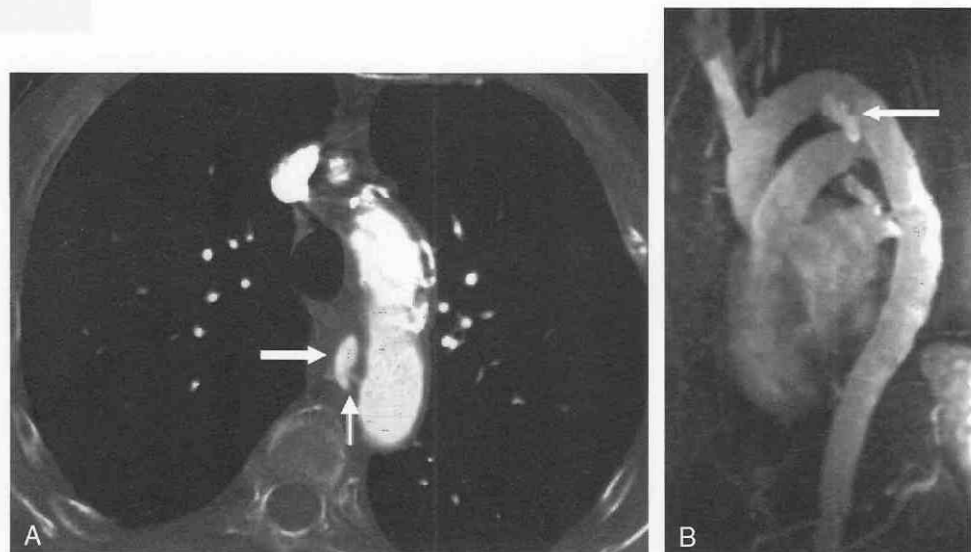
A, Axial CT scan in an elderly woman with acute back pain. There is a collection of contrast material medial to the descending aorta (*thick arrow*) that has a narrow but discrete communication with the aortic lumen (*thin arrow*). B, Sagittal oblique maximum intensity projection from gadolinium MR angiography delineates the focal atherosclerotic ulcer and its relationship with the aortic lumen (*arrow*).
